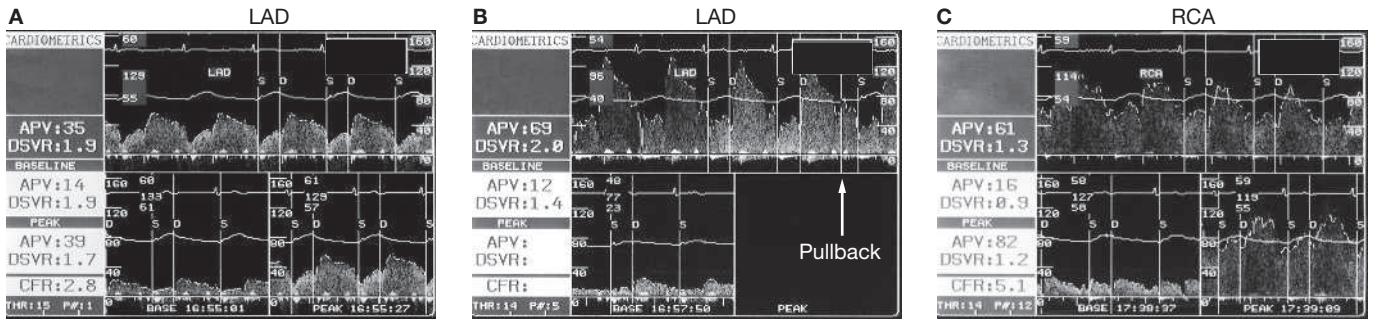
Intracoronary Doppler ultrasound scans demonstrating blood flow in the stenosed LAD and the non-stenosed RCA. (A) On injection of 30 µg adenosine, coronary blood flow in the LAD increased from 14 to 39 cm/s, corresponding to a CFR of 2.8. (B) During pullback in the LAD, coronary blood flow across the lesion increased 5.75-fold, from 12 to 69 cm/s. (C) In comparison, adenosine induced a blood flow increase from 16 to 82 cm/s in the RCA, equivalent to a CFR of 5.1. The fractional flow reserve of the LAD was, therefore, 0.55 (normal >0.75). A series of patients with normal coronary arteries documented that fewer than 1% of subjects had a CFR greater than 5 and a flow greater than 80 cm/s.⁴ Abbreviations: APV, average peak velocity; CFR, coronary flow reserve; DSVR, diastolic/systolic velocity ratio; LAD, left anterior descending artery; RCA, right coronary artery.
